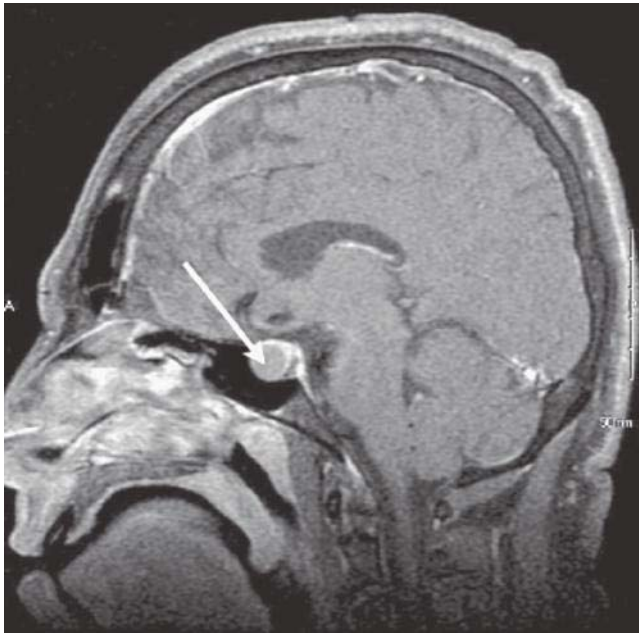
Pituitary adenomas are usually isointense to the gland on noncontrast T1-weighted magnetic resonance images; on contrast administration, the normal gland enhances early, as visualized on this sagittal image, whereas the adenoma (arrow) continues to remain unenhanced. With late imaging, the adenoma enhances.
